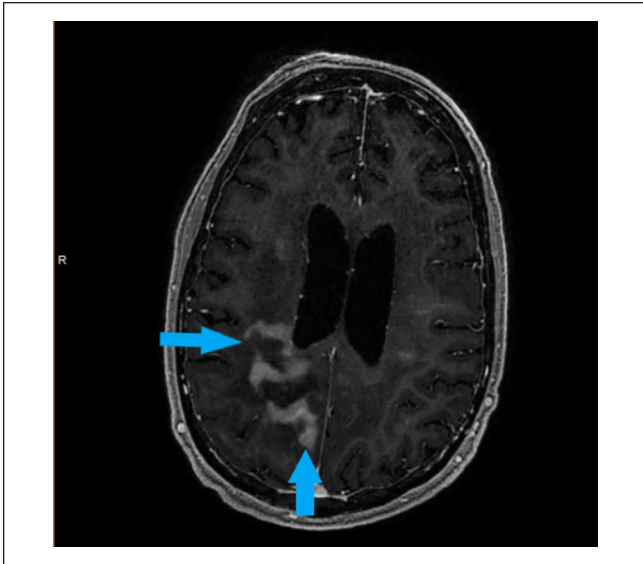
Magnetic resonance imaging of the brain showing intracranial white matter enhancements consistent with disease progression (blue arrows).
